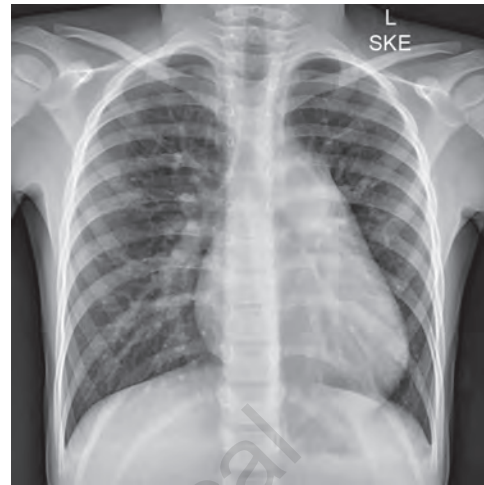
X-ray in large atrial septal defect. Note dilated main pulmonary artery (MPA) and prominent vascularity.
